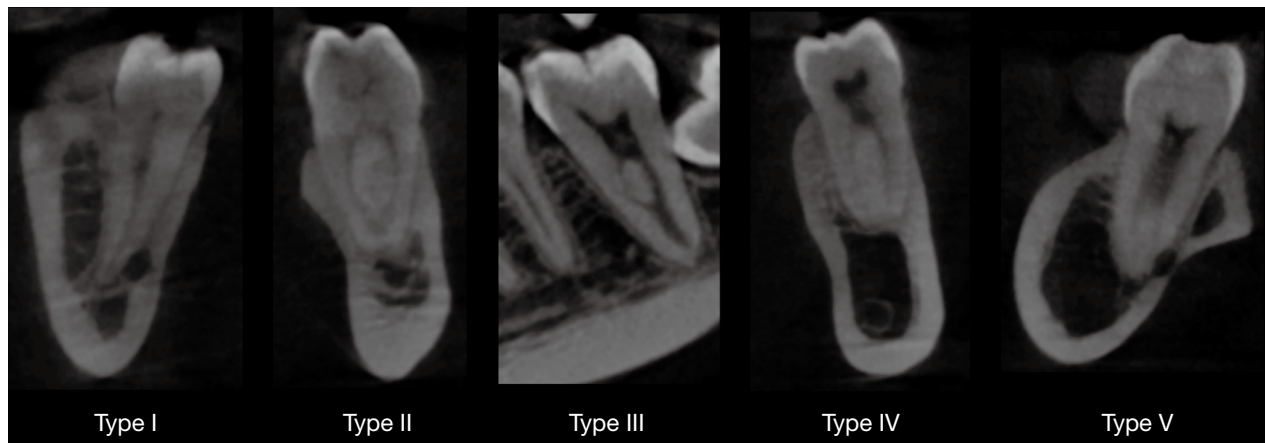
Coronal (types I, II, IV, and V) and sagittal (type III) cone-beam computed tomography reconstructions of the most frequent types of root canal anatomic variations evaluated in the lower molars according to the Vertucci classification.
